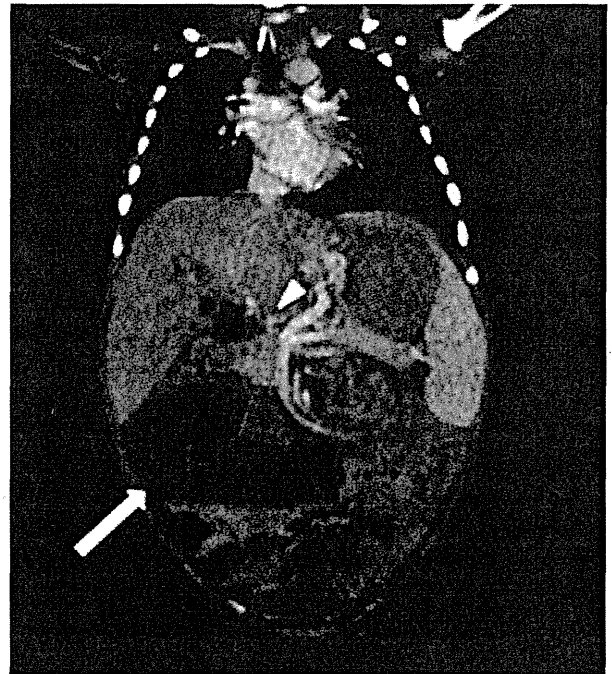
Enhanced abdominal computed tomography demonstrated dilated loops of intestine with wall thickening at the Roux-Limb (white arrow) and narrowing of the portal venous trunk (white arrowhead).
